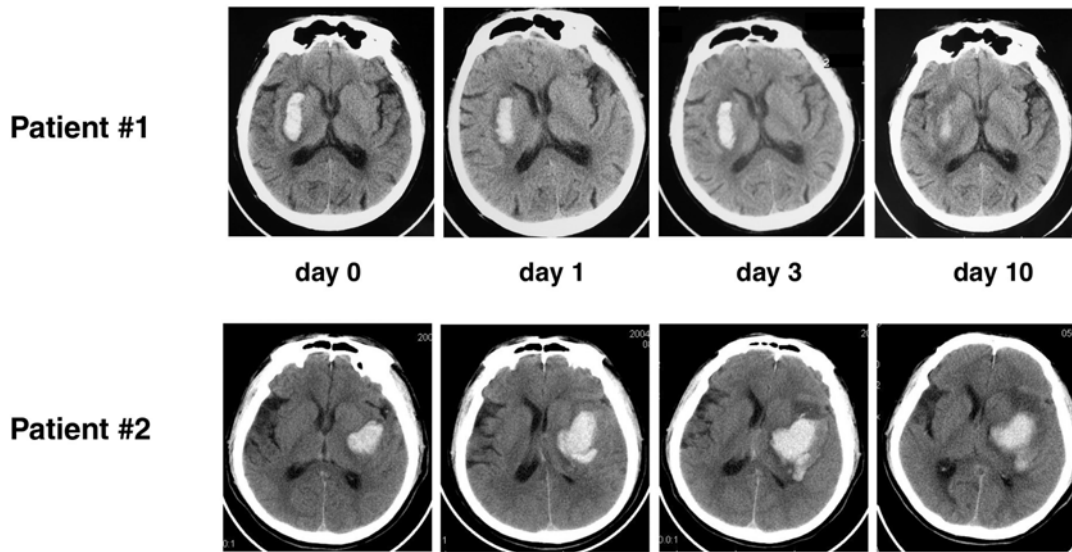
Serial CT scans of 2 ICH patients
